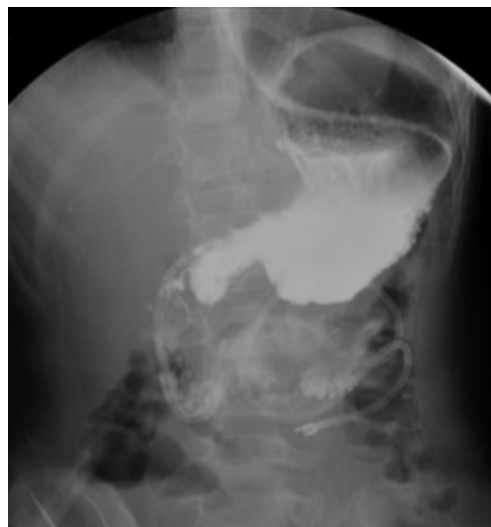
Postoperative gastrointestinal tract radiography imaging. No filling defect in the stomach or duodenum.
